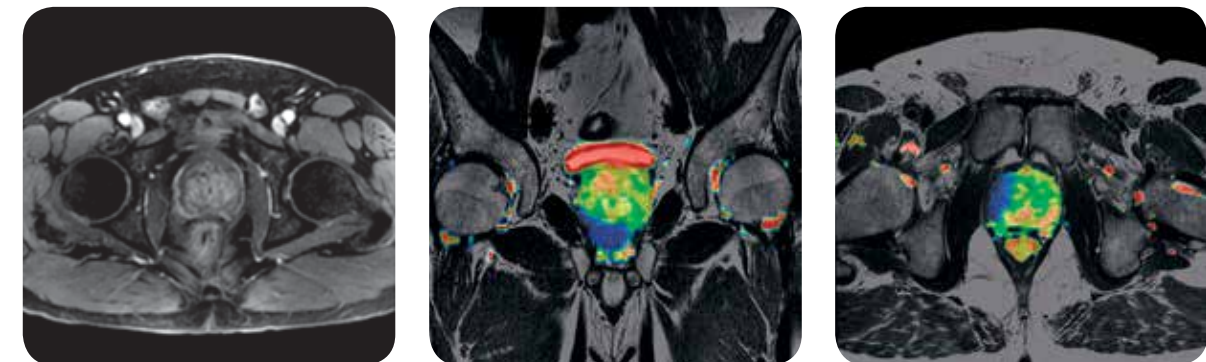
Fat suppressed LAVA (left) and high-resolution Axial and Coronal T2-weighted FSE with ADC overlaid using READY View, demonstrating area of low ADC in apex of the prostate.
